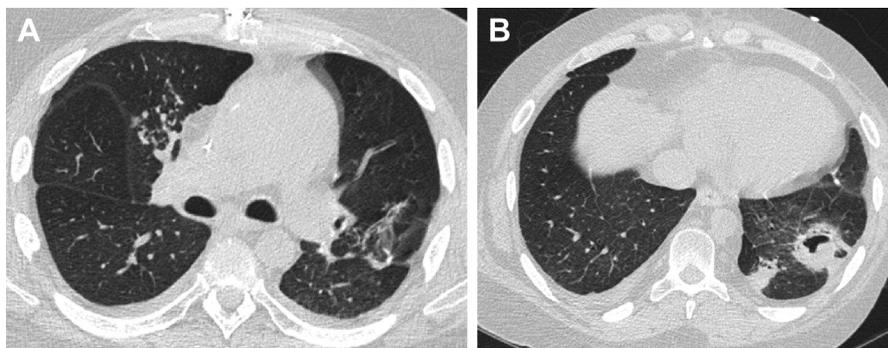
57-year-old man status postcardiac transplant, with *M kansasii* infection. Axial chest CT images show tree-in-bud nodules in the right upper lobe and a left lower lobe cavity, representing a lung abscess.
